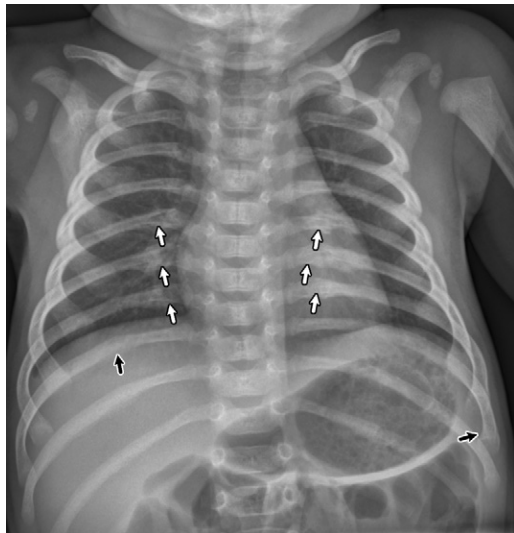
Nonaccidental trauma in a 1-month-old boy. Frontal chest radiograph shows multiple fractures of variable ages, including acute fractures (black arrows) of the left anterior ninth rib and right posterior ninth rib, as well as healing fractures of the bilateral sixth to eighth posterior ribs (white arrows).
